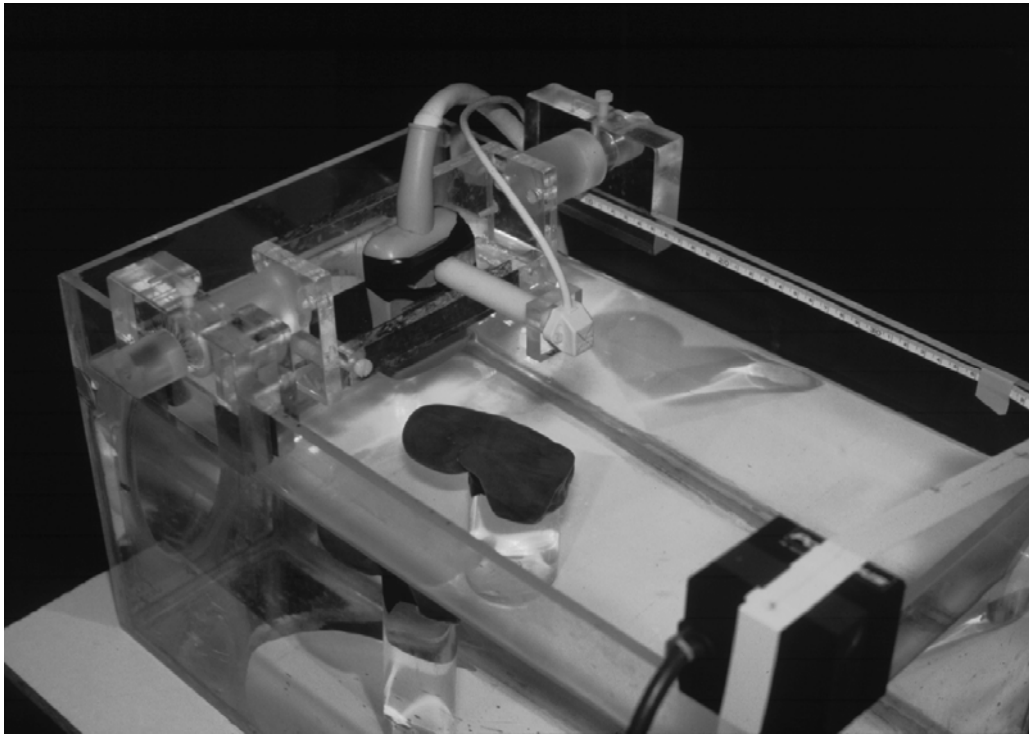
Kidney on a Perspex plinth within the scanning tank. The Polhemus receiver can be seen attached to the ultrasound probe by a plastic rod. The transmitter is on the bottom right of the picture.
